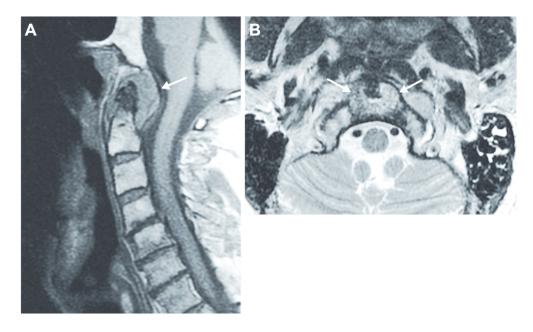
Atlanto-axial pannus in a 68-year-old male with a 6-year history of seropositive RA. (A) Sagittal T1-weighted MRI image demonstrating a soft tissue mass surrounding the odontoid process with mass effect on the thecal sac and spinal cord. There is associated bony erosion and abnormal marrow signal. (B) Axial T2-weighted MRI image from the same patient.
